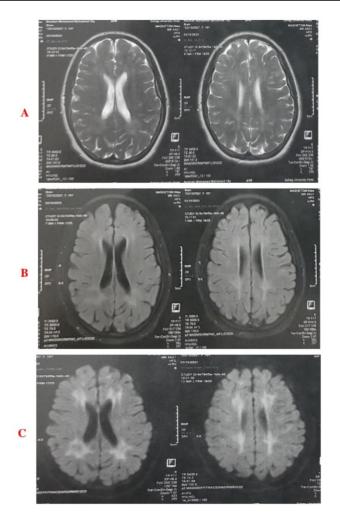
Brain Magnetic Resonance Imaging (MRI) findings of patient number (19): 16 years old female diagnosed as classic PKU at age of 4 years old with moderate mental delay, not compliant to low phenyl alanine diet. Axial brain T2 (A), FLAIR (B) and diffusion (C) at the ventricular level: The images show bilateral periventricular white matter increased T2/FLAIR signal, with corresponding diffusion restriction. Normal brain cortex and no other abnormalities.
